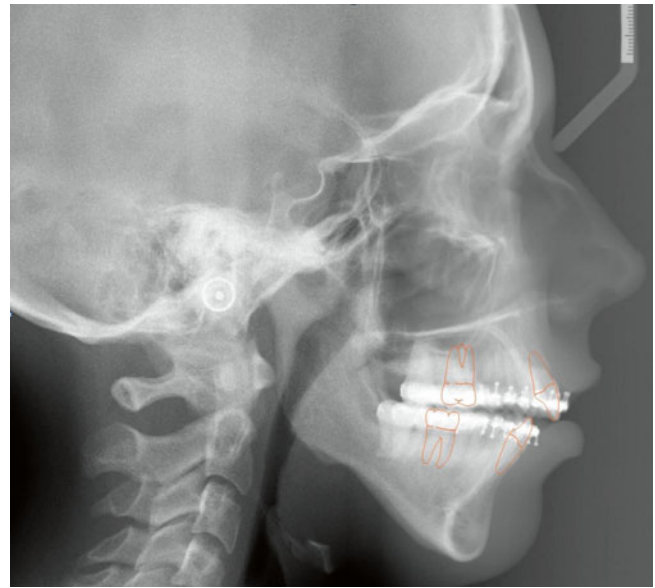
Standardized lateral cephalometric radiograph. Overlapping structures between the left and right may be difficult to distinguish as are the dentition. In this particular radiograph, the central incisor and first molar are marked. There is a soft-tissue filter in the modern units that enhances the profile. Notice also that the posterior airway space can be identified
